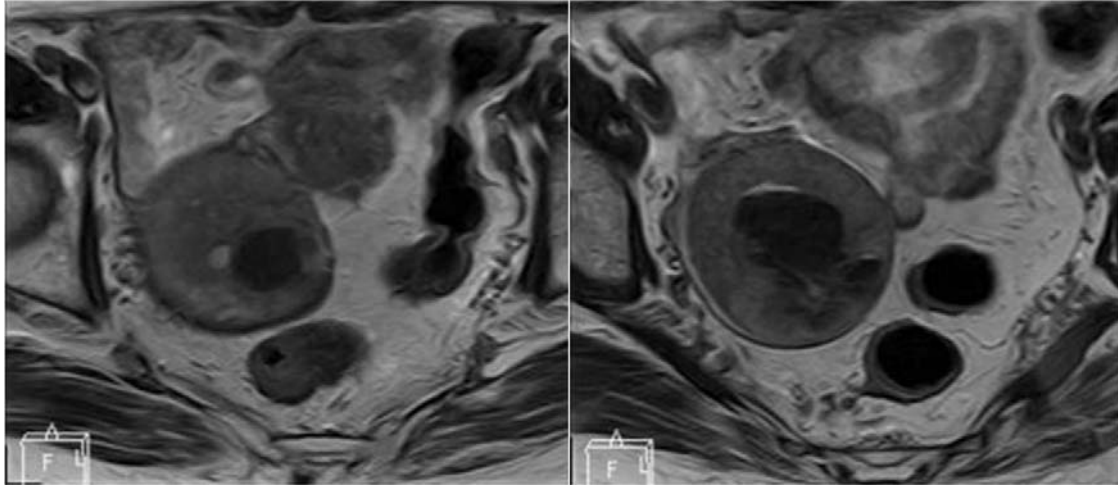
Corresponding images of MRI pelvis: confirming the right adnexal mass and the rectal primary.
